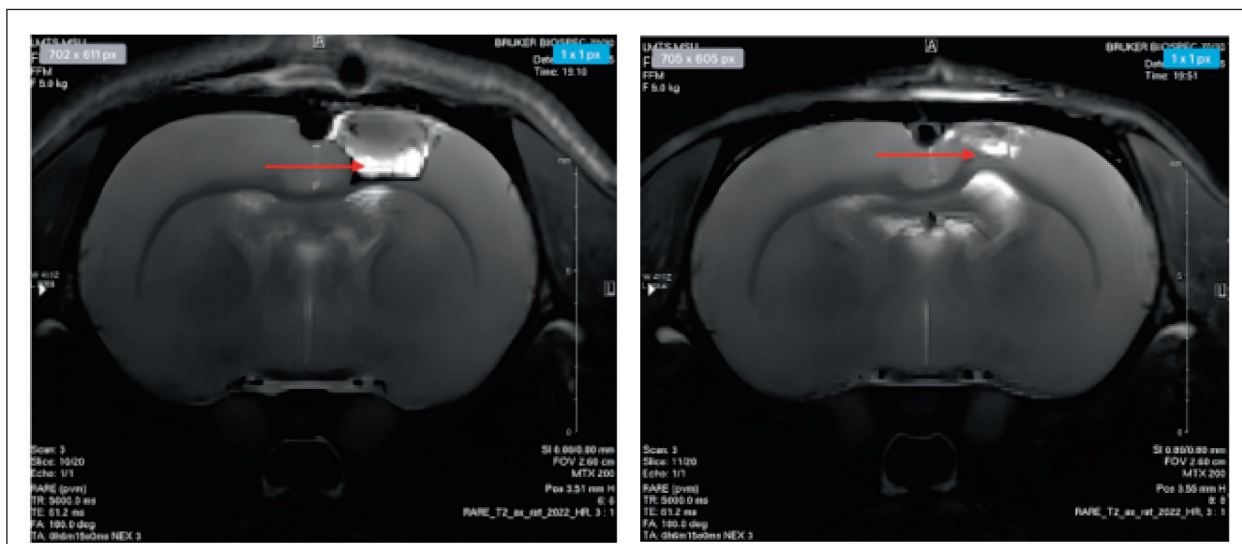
T2-weighted MRI images in the axial plane, acquired on a 7-Tesla scanner (BioSpec 70/30 USR, Bruker).
